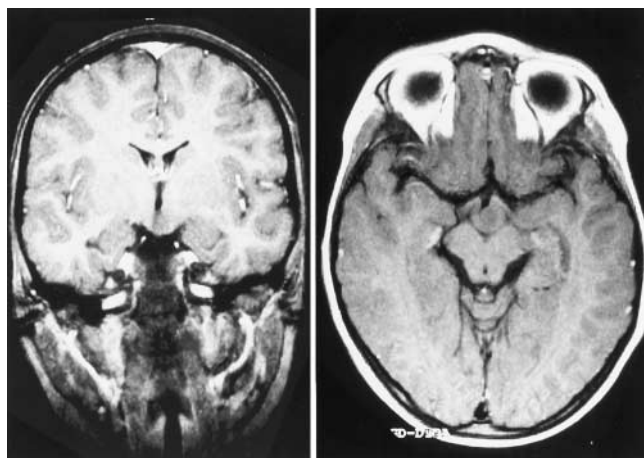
Case 2. Gadolinium-enhanced T₁-weighted coronal (left) and axial (right) MR images obtained before radiosurgery in a 6-year-old girl with a sessile hypothalamic hamartoma measuring 11 mm in diameter.
